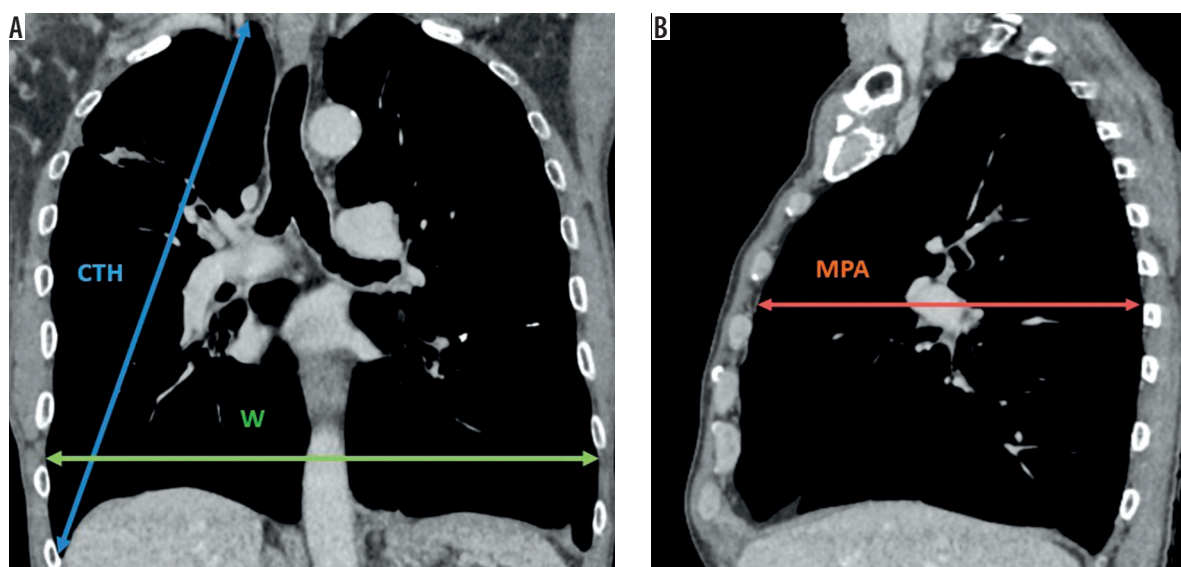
Measurement of chest wall dimensions on pre-biopsy thoracic computed tomography. (A) Coronal reconstruction of the thorax: following Chang *et al.* [21], chest height (CTH) was defined as the distance between the lung apex and the costophrenic angle (indicated by the blue double arrow). Maximum chest width (W) was defined as a strictly horizontal line (green double arrow). (B) Sagittal reconstruction of the thorax: the maximum posteroanterior (MPA) distance was defined according to Peters *et al.* [20] (red double arrow). All distances are expressed in millimeters
